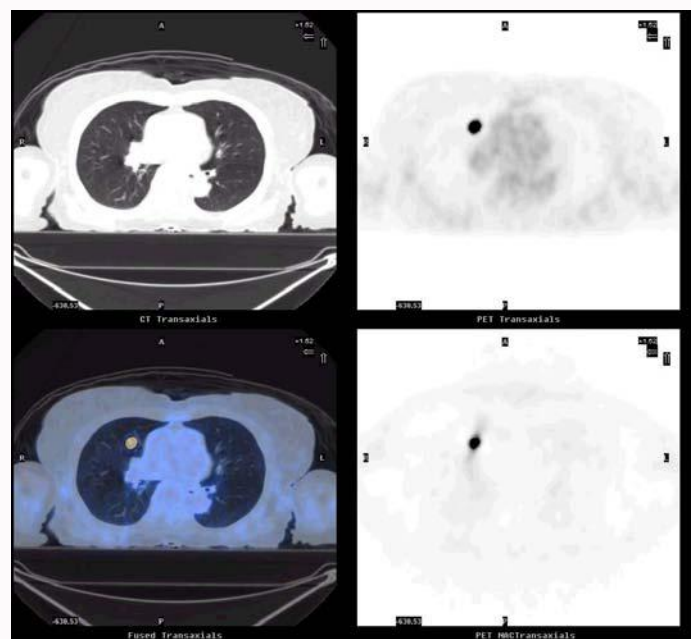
A 75 year-old-female with SCC from the base of the tongue. PET+CT evaluation showed focal FDG-18 uptake with intense activity without corresponding CT abnormality. (Upper right = attenuation corrected (AC), Lower right = non attenuation corrected, Upper left = CT scan of the corresponding site, lung window and Lower left = PET, AC +CT fused image).
